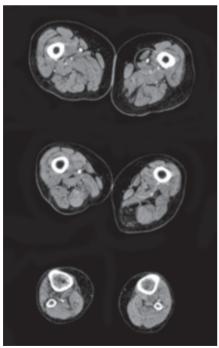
Computed tomography angiography scan showing that superficial femoral artery is interrupted just after entering the Hunter's canal (upper and middle sections) and the absent distal filling at the infragenicular portion (lower section).
